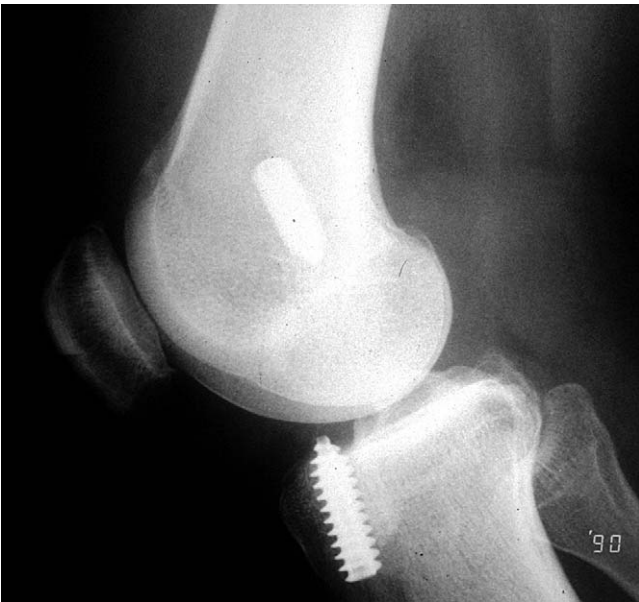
Lateral radiograph showing anterior malpositioning of the tibial tunnel.
